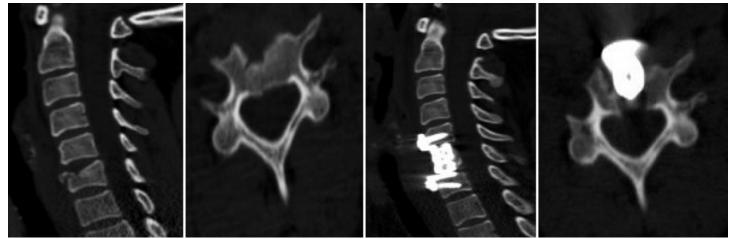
33-year-old female patient AITK, C6 burst fracture, CT image after C6 corpectomy + Anterior cage application.
